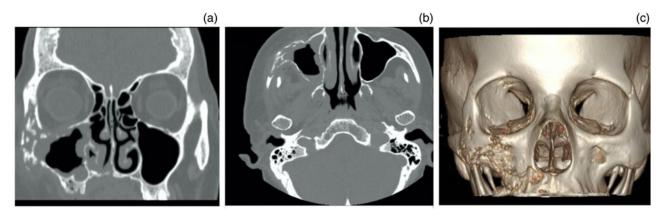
(a) Coronal and (b) axial two-dimensional, and (c) three-dimensional computed tomography images showing destruction of right anterior maxillary wall, alveolar process and zygomatic process.
